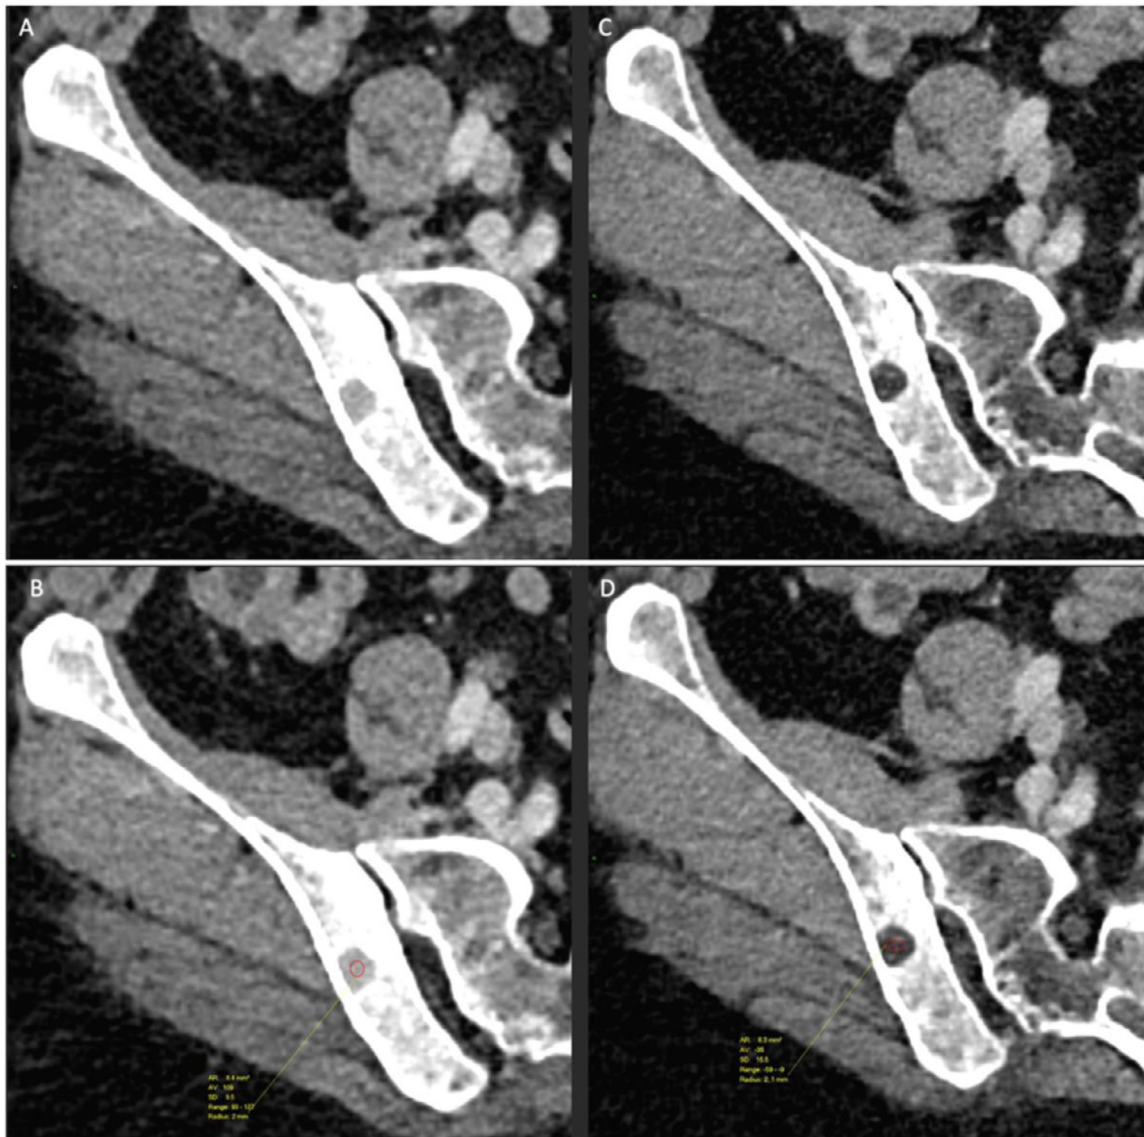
(A, B) Initial staging CT demonstrates a lytic bony lesion involving the right ilium with soft tissue component and mean CT attenuation threshold of 109 HU, appearances are consistent with lytic bone metastases. Images C and D show postsystemic treatment surveillance CT which shows the previous right iliac bony lytic lesion now demonstrating complete fatty replacement (measured Hounsfield unit -35) in keeping with response to treatment.
